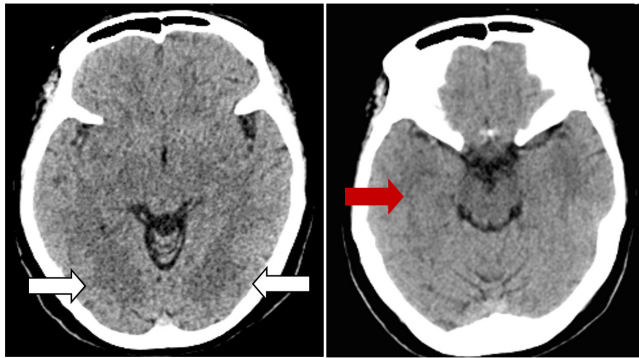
Cranial CT scan showed hypodense areas in both parietotemporooccipital regions (white arrows) and small acute infarcts in right centrum ovale (red arrow).
